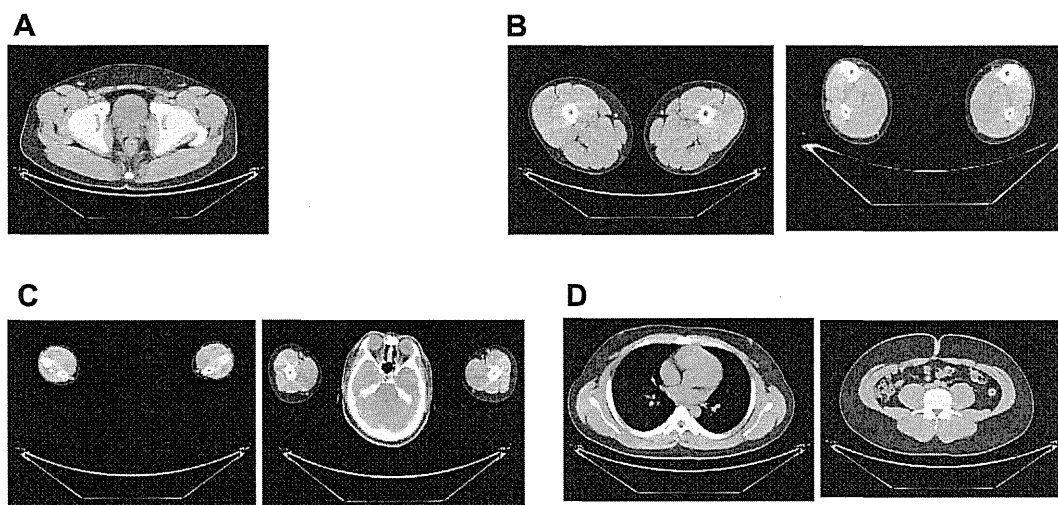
Computed tomography (CT) images of various regions of the patient's son (Patient 2) were obtained to evaluate fat distribution. A. CT images taken at the level of the gluteal fat were obtained. B. CT images taken at the level of the thigh are shown in the left panel, while images taken at the level of the calf are shown in the right panel. Patient 2 had decreased amounts of subcutaneous fat, particularly in the lateral thigh and calf regions. C. CT images taken at the level of the forearms are shown in the left panel, while images taken at the level of the arms are shown in the right panel. Patient 2 had decreased amounts of subcutaneous fat, particularly in the lateral forearms. D. Thoracic CT images taken at the level of the fourth thoracic vertebrae are shown in the left panel, while abdominal CT images taken at the umbilical level are shown in the right panel.
